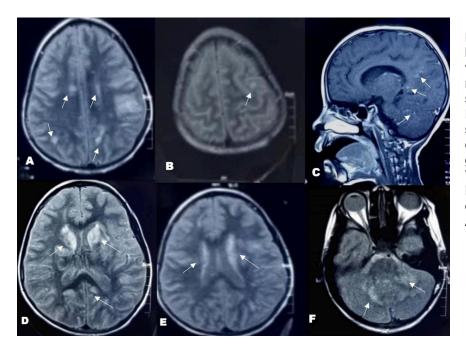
Axial sections of brain MRI at admission fluid-attenuated inversion recovery (FLAIR) echo spin sequences (A, B, D, E, F) alongside, a sagittal section in T1-weighted echo spin following gadolinium injection (C). images These reveal Multiple areas of demyelination indicative of ADEM
